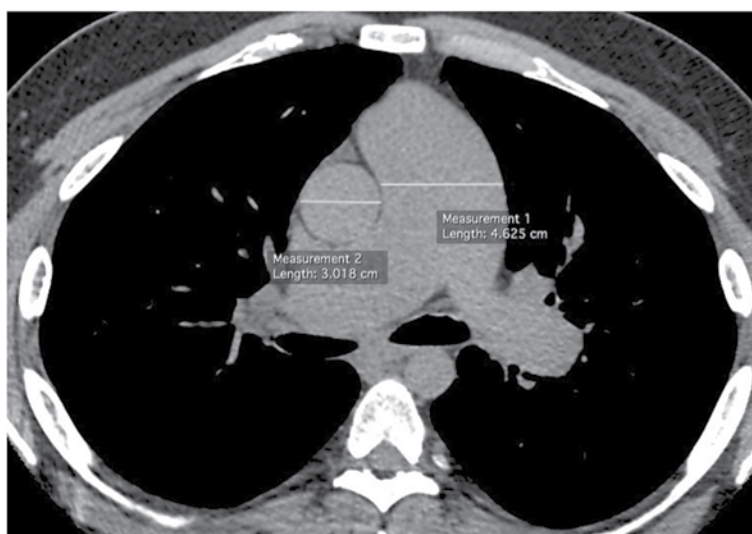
Axial chest CT scan with mediastinal window settings shows an increased pulmonary artery diameter (46 mm — normal up to 29 mm). Also note that this diameter is greater than the aortic diameter measured in the same plane (30 mm).
